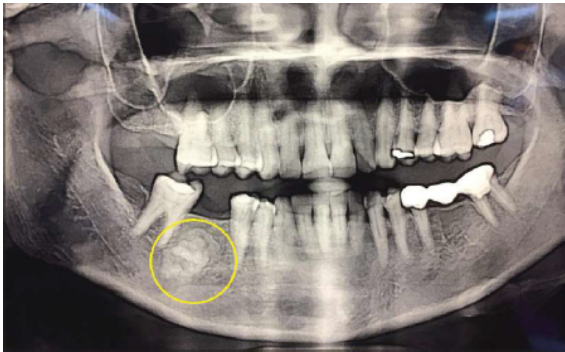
Focal cemento-osseous dysplasia — Orthopantomogram showing a well-defined radiopaque mass in the right mandible region extending from the distal root of 45 to the mesial root of 47.¹⁶
